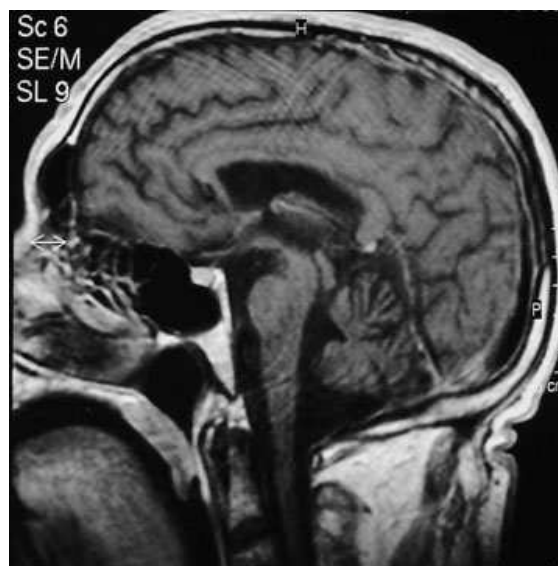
Brain MRI (T1-weighted sagittal image) of the patient shows cerebellar atrophy.
